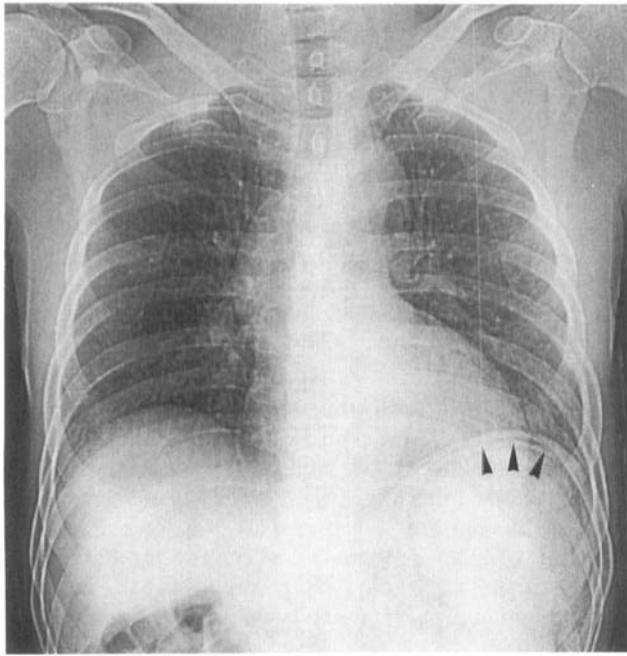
Chest radiograph demonstrating a crescent-shaped region of gas under the left diaphragm (arrowheads).
